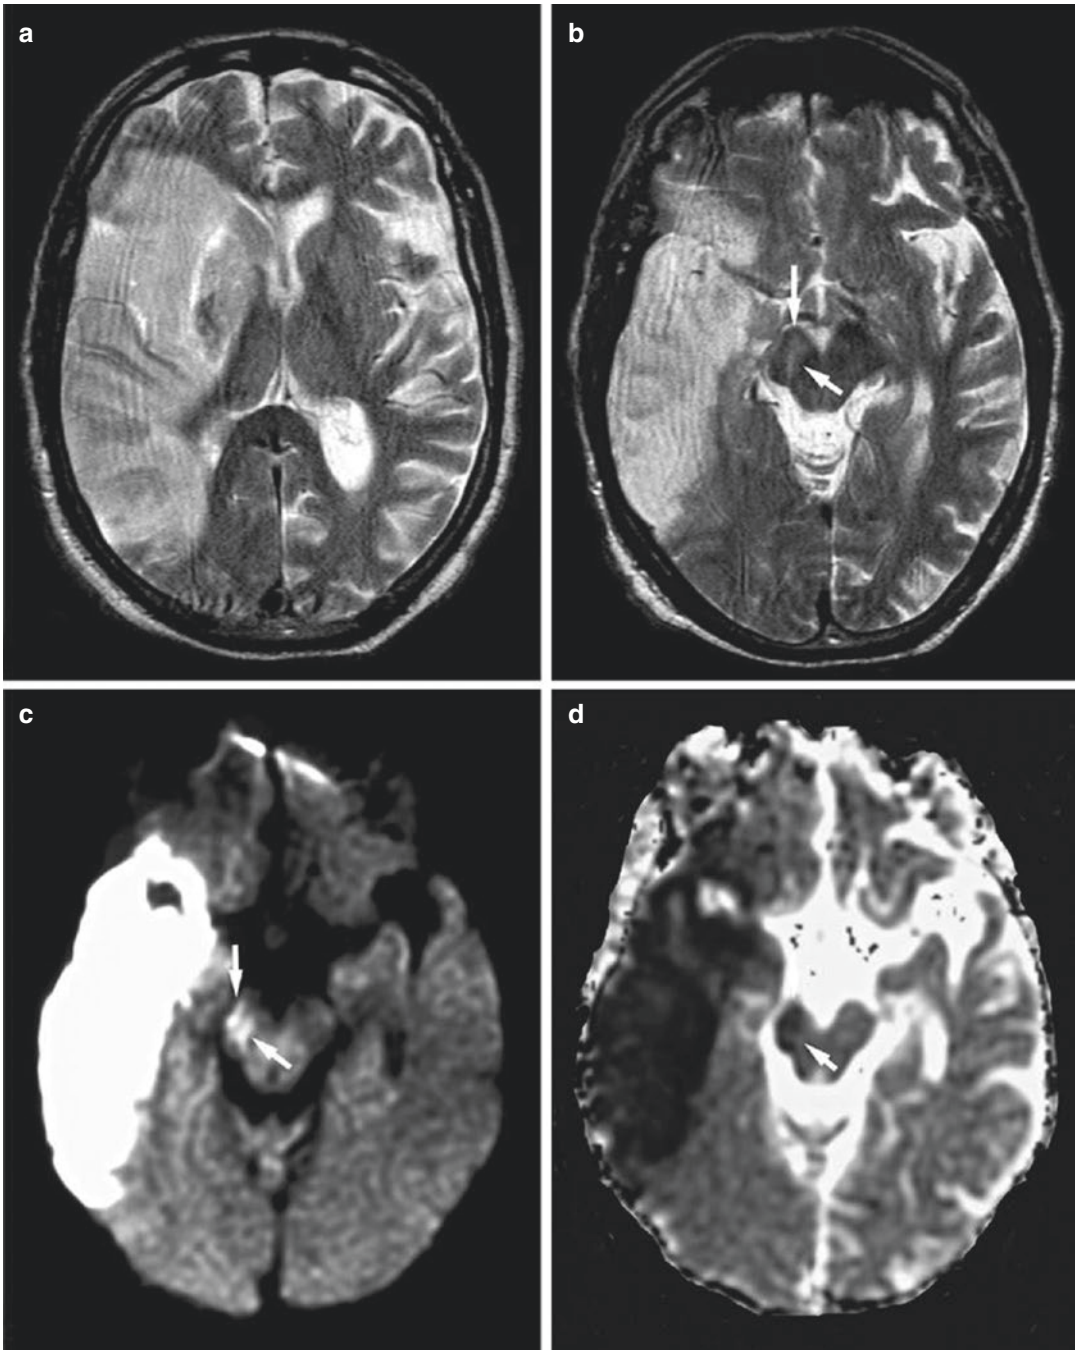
Wallerian and transneuronal degeneration (acute phase) in a 76-year-old man with a large infarct in the right middle cerebral artery (MCA) territory (6 days after onset). (a) T2-weighted image shows a right MCA infarct as hyperintense, including the left putamen. (b) T2-weighted image at the level of the midbrain reveals a
